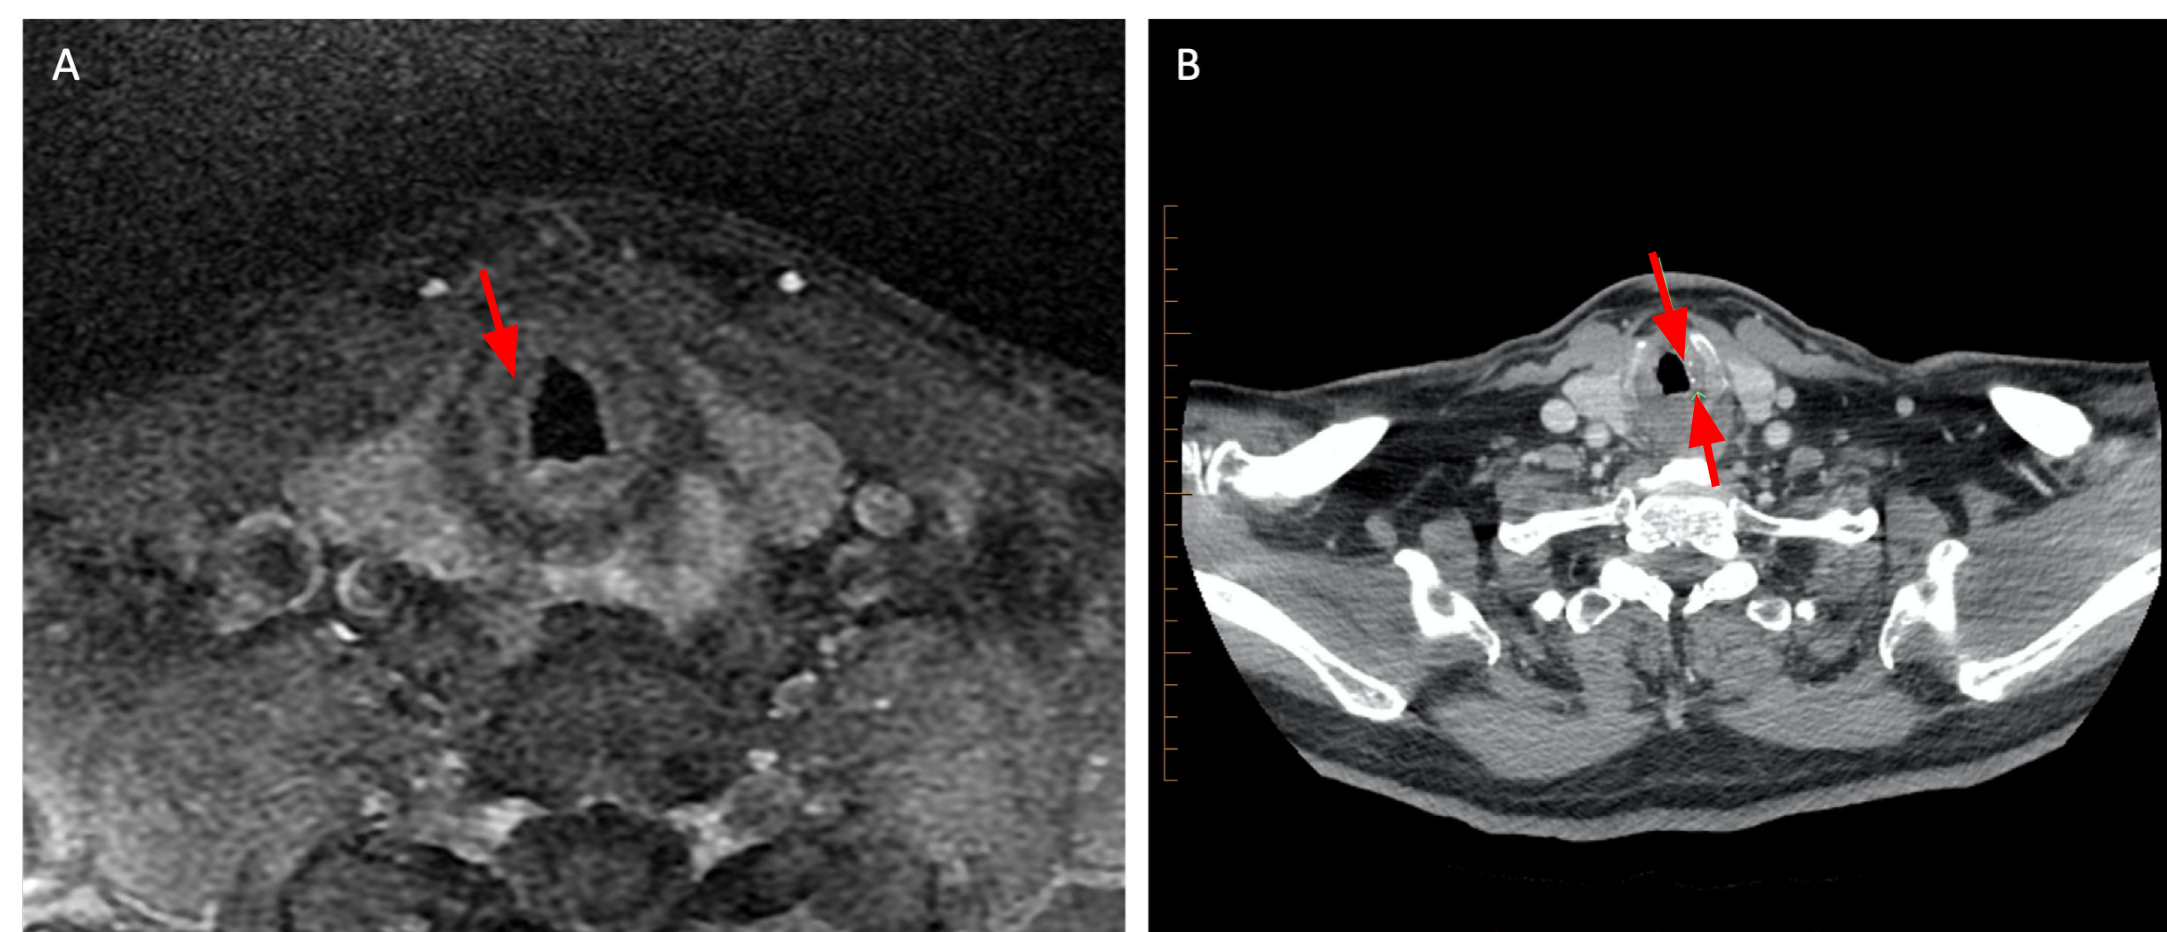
Axial T1-weighted fat suppressed MRI at the level of the upper trachea demonstrating tracheal extension (A) and axial CT neck with contrast demonstrating punctate calcifications in a subglottic lesion (arrows) (B).
